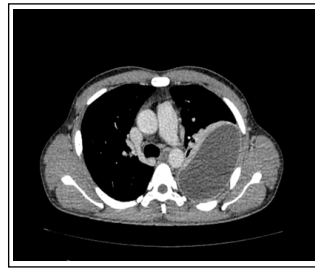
CT Thorax revealed left encysted pleural effusion (red arrow)
